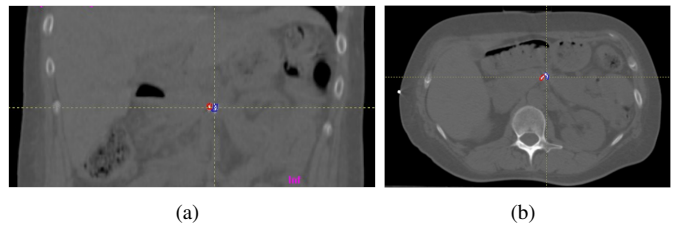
Two fiducial markers delineated by red and blue outlines. (a) A coronal slice of the reference CT. (b) An axial slice of the reference CT.
